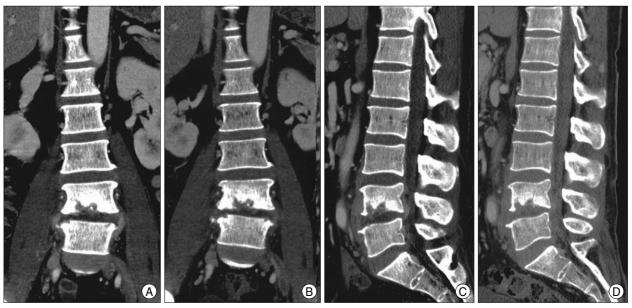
A, B: Initial coronal (A) and sagittal (C) enhanced computed tomography (CT). C, D: Follow-up coronal (B) and sagittal (D) enhanced CT 4 weeks after antimicrobial treatment. Compared to initial CT, follow-up CT shows interval improvement of paravertebral and epidural inflammation.
